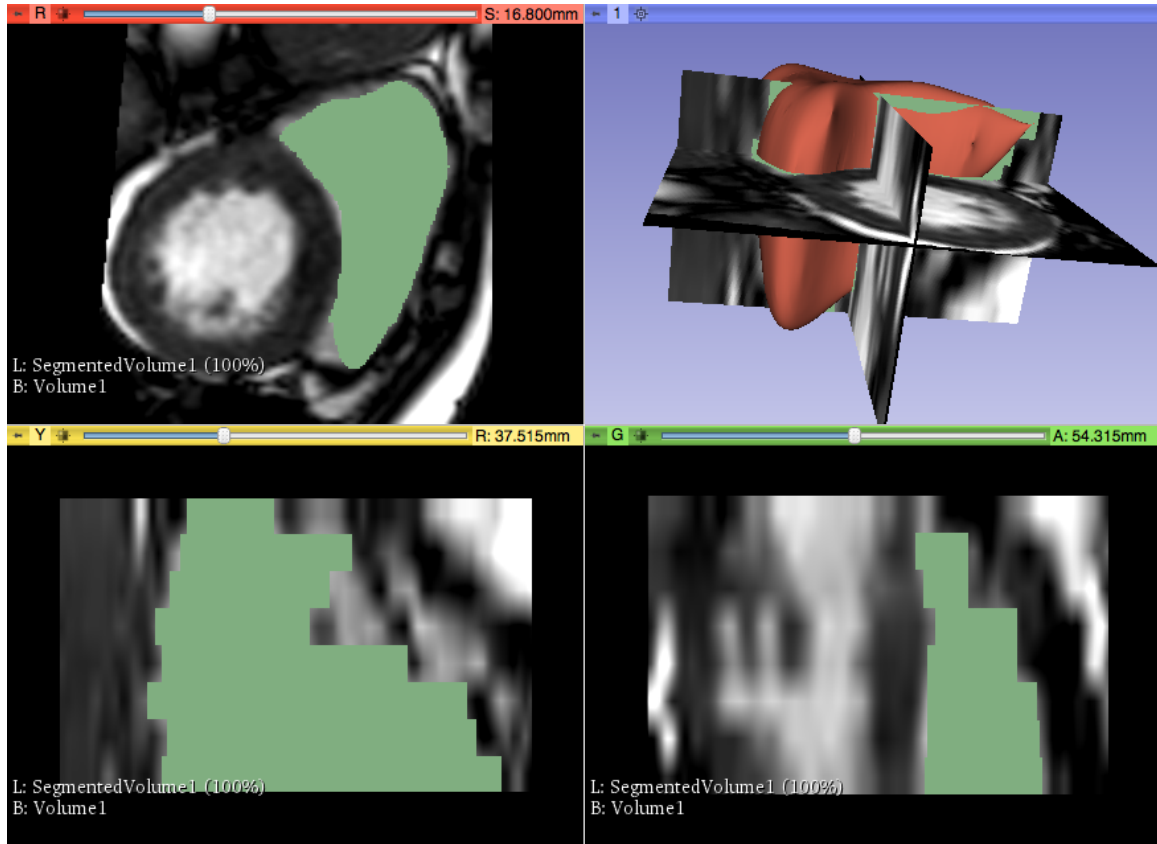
Axial, Sagittal, Coronal, and the 3D model (counter-clockwise from top left) of the segmented RV blood pool overlaid onto the MRI image.
